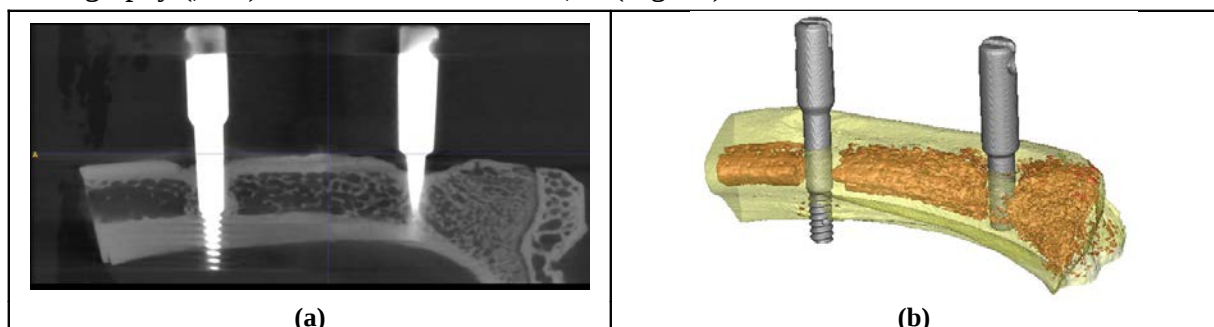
(a) a μ CT image of the sample; (b) a 3D segmentation with differentiation of materials.
